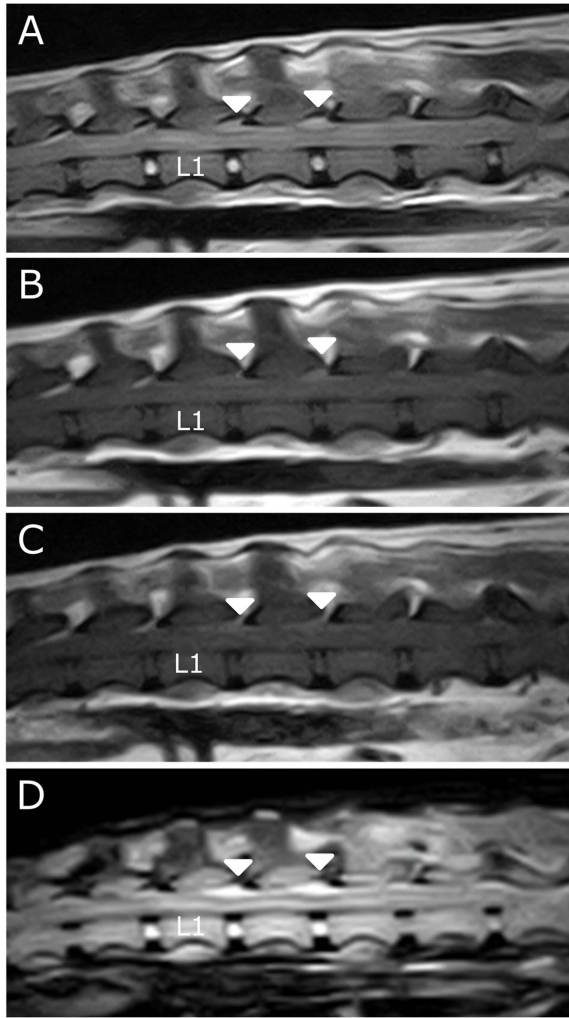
On sagittal magnetic resonance images, a high-signal lesion was detected in T2-weighted (A), T1-weighted (B), contrasted T1-weighted (C), and fat suppression (D) images. There were lesions within the spinal canal at L1-L3 intervertebral disc space that were located dorsally.
